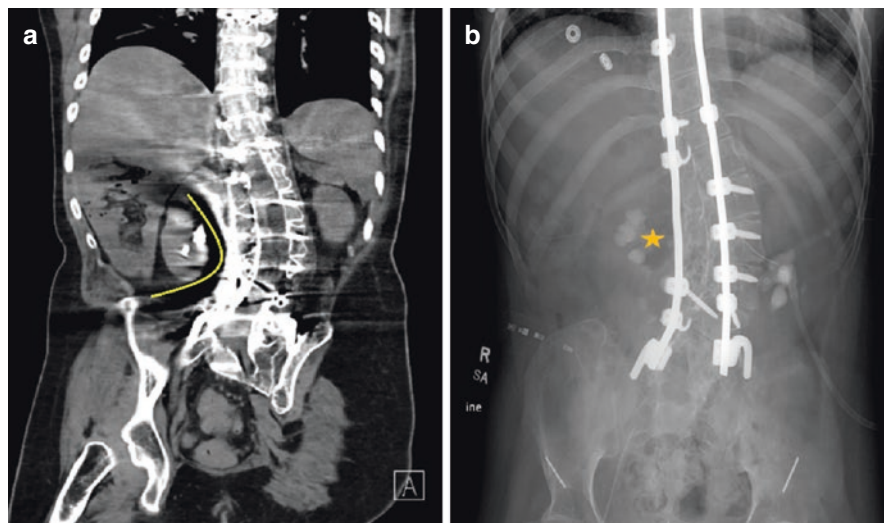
Artifact from spinal rods on a CT image (a) obscures full assessment of right renal calculus burden (yellow curve). The corresponding abdominal radiograph (b) shows the full extent of the right renal staghorn calculus (orange star)
